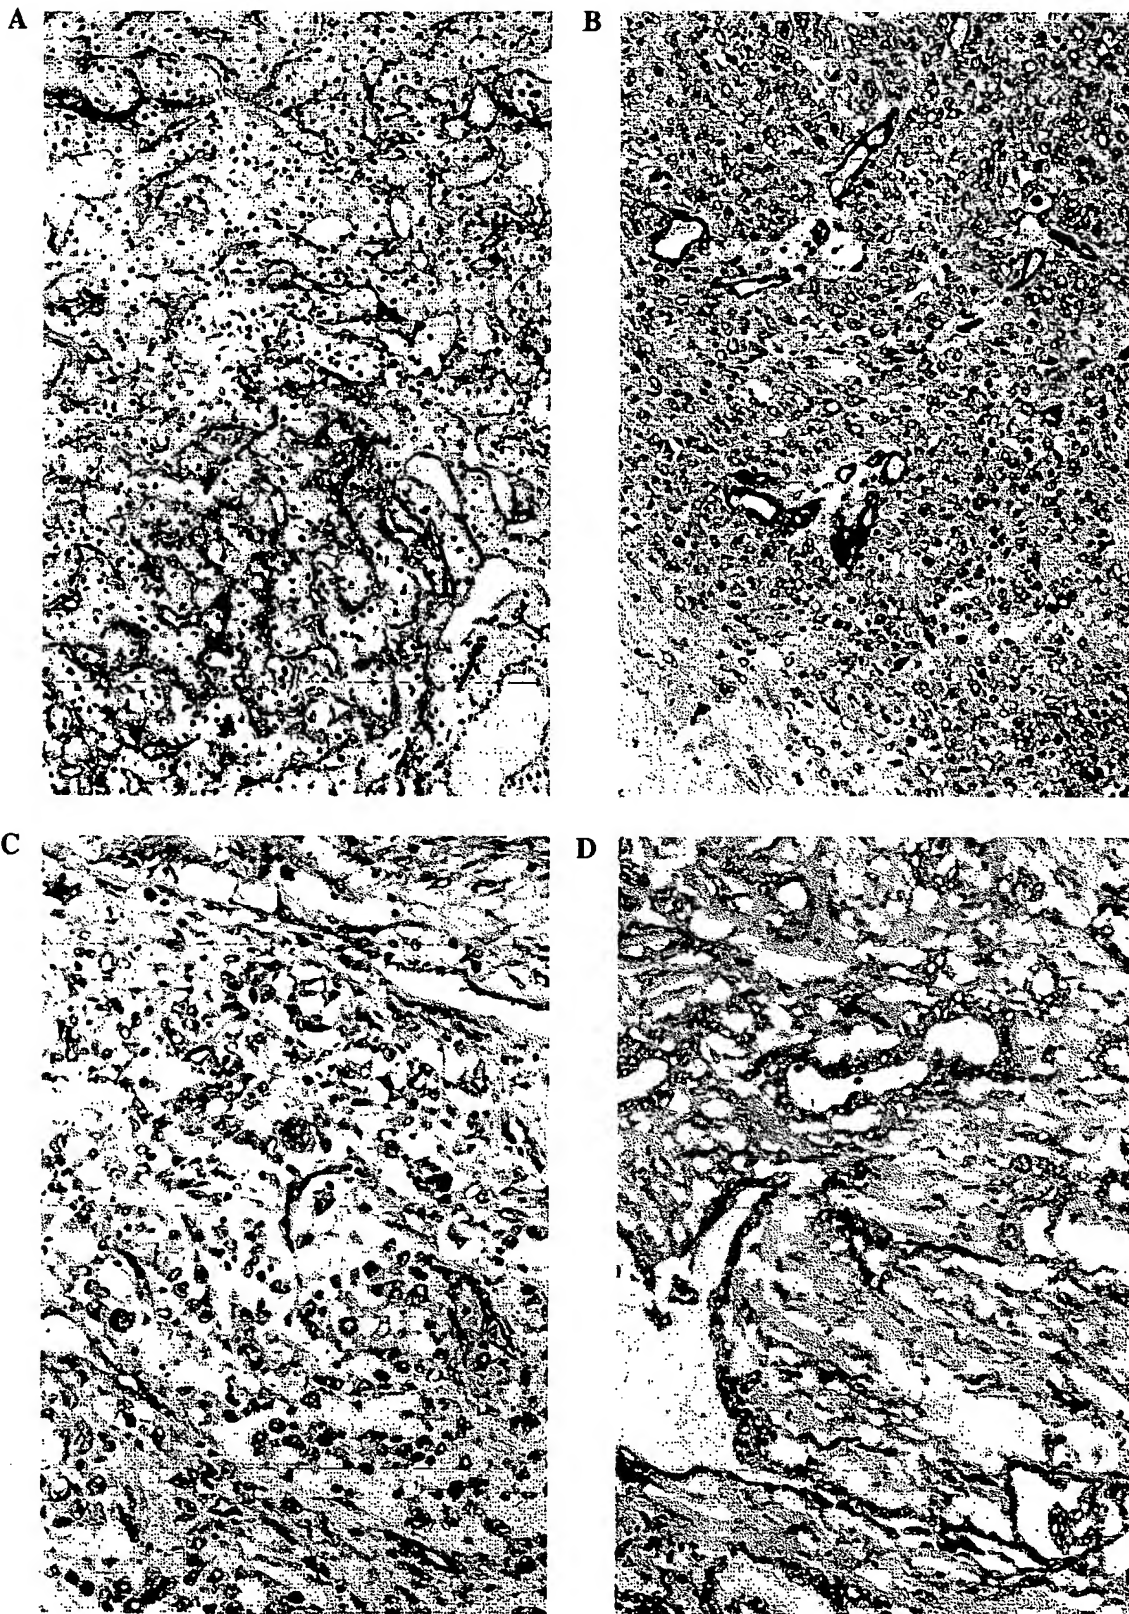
Tumor-associated neovasculation expresses PSMA. (A) Conventional (clear cell) renal cell carcinoma. (B) Lung cancer. (C) Soft-tissue sarcoma. (D) Pancreatic cancer.
